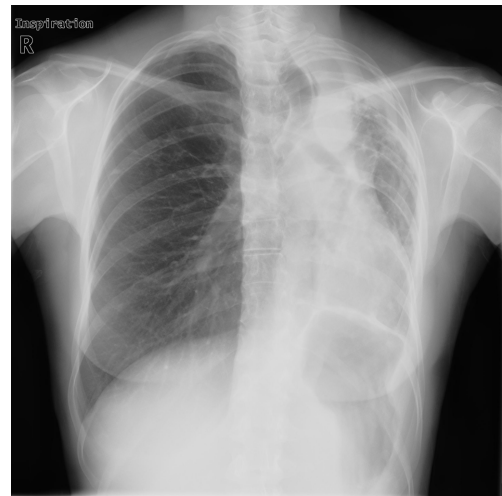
Follow-up chest radiograph after autologous blood and minocycline pleurodesis showing complete resolution of the pneumothorax and full re-expansion of the left lung.
